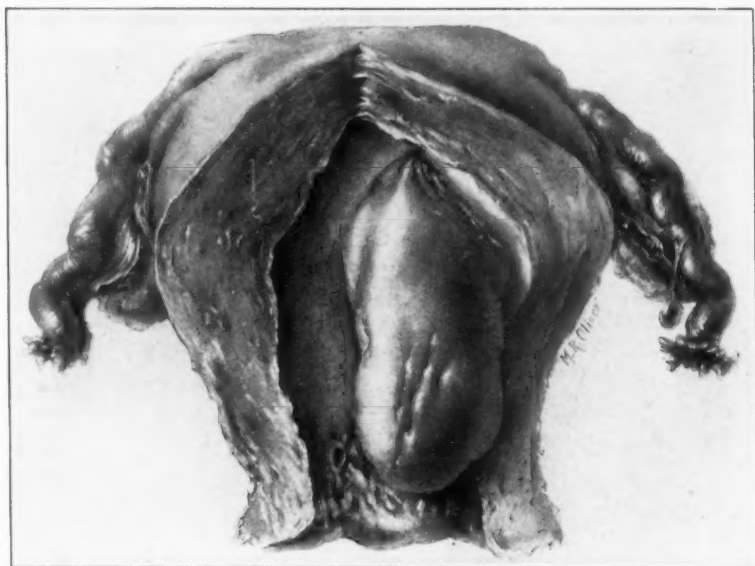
Pedunculated fibroid with terminal necrosis producing metrorrhagia. Radium or x-ray will increase the necrosis.
